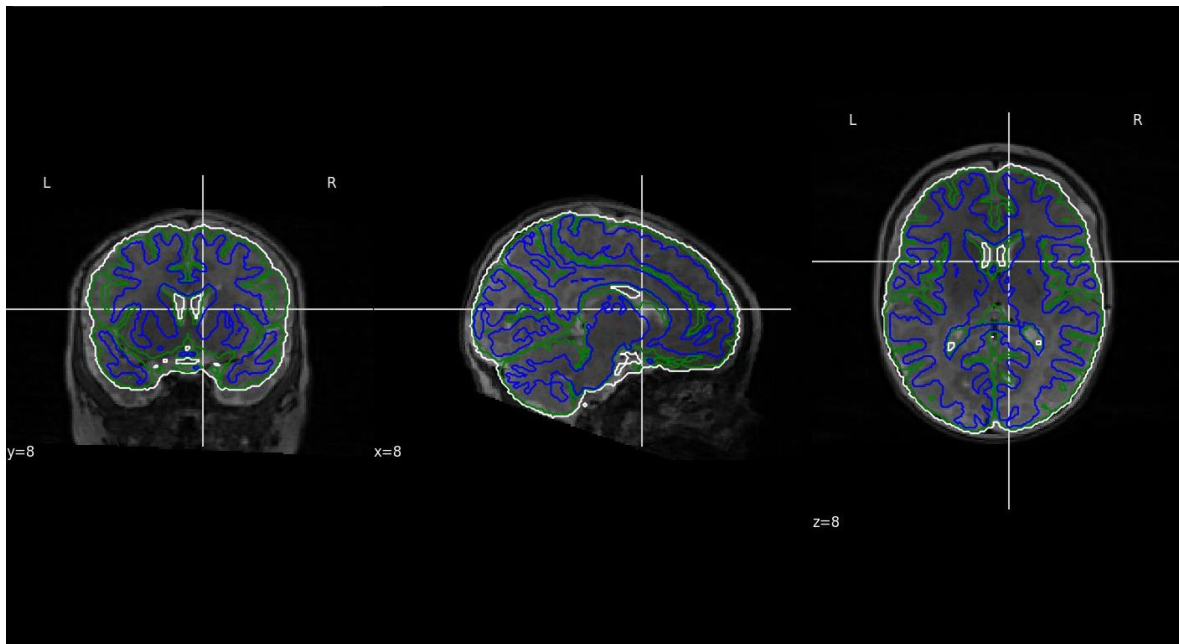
Quality Control (77 of 100 subjects): overlay of the T2-weighted anatomical for an example subject on the segmented infant template.
